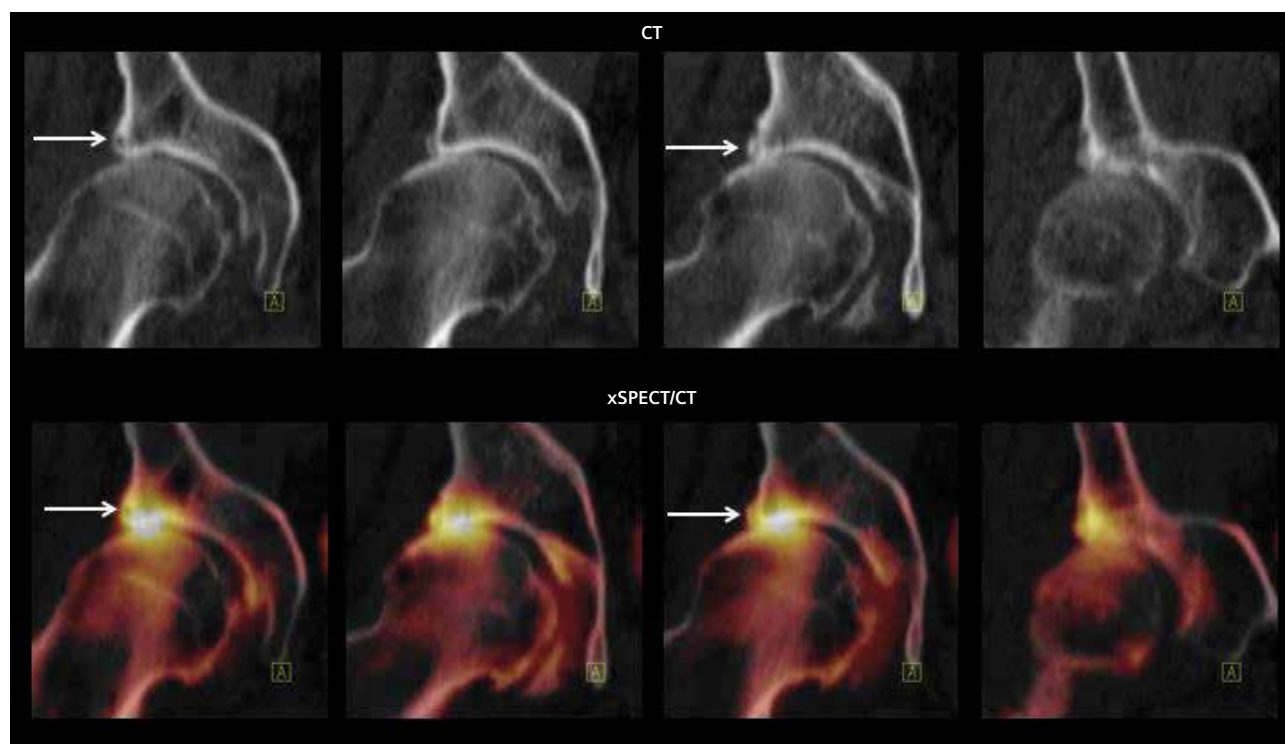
Serial coronal slices of CT and fusion of CT and xSPECT Bone show a tear of the right acetabular labrum and corresponding hypermetabolism in the torn acetabular labrum and adjacent femoral head. The CT images show femoro-acetabular impingement of the cam type, with the superior acetabular labral edge impinging on the adjacent superior femoral head surface with resultant localized hypermetabolism.
